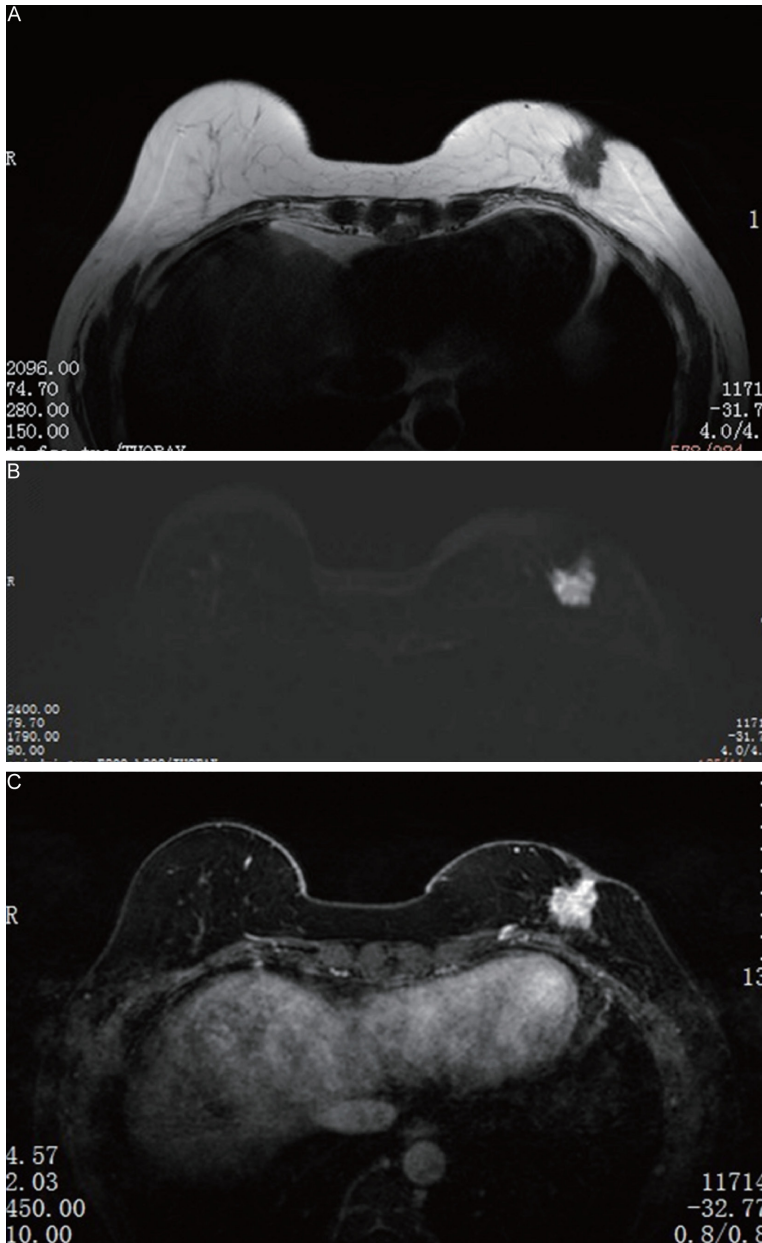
DCE-MRI image of a 54-year-old patient. A: STIR, short-tau inversion recovery; B: DWI, diffusion weighted imagine; C: DCE-MRI, dynamic contrast enhanced magnetic resonance imaging.
